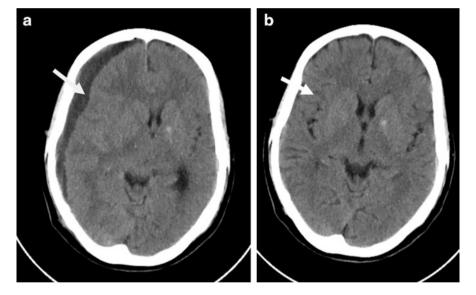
(a) CT scan showing CSDH (white arrow) causing mass effect, pressure on the right side of the brain and brain shift. (b) CT scan after surgery showing good result with no collection of blood (white arrow)
